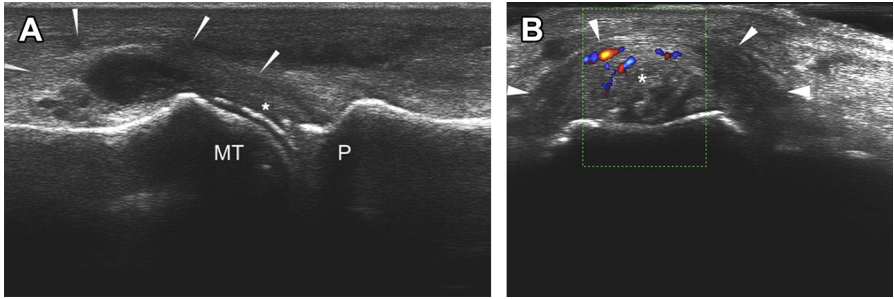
(A) Ultrasound image of a first metatarsophalangeal joint with double-contour sign (*asterisk*). White arrows outline the synovial lining. MT, metatarsal head; P, phalangeal head. (B) Ultrasound image of a metatarsophalangeal joint in transverse orientation with hyper-echoic tophi and increased Doppler signal indicating active inflammation (*asterisk*). Arrows outline the synovial lining.
